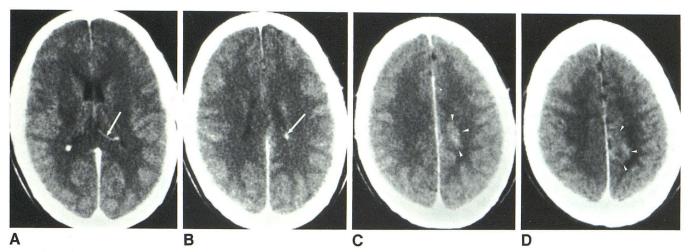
Contrast-enhanced CT scans. A and B, Enhancing dilated transcerebral draining vein (arrows). C and D, Enhancement in body of venous angioma (arrowheads).
